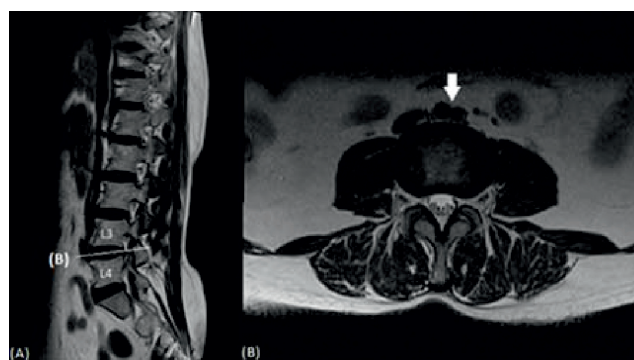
MRI images of : (A) T2W parasagittal section of spine with typical normal lumbosacral junction (B) T2W axial section of spine shown in (A) at L3-L4 showing aortic bifurcation.
